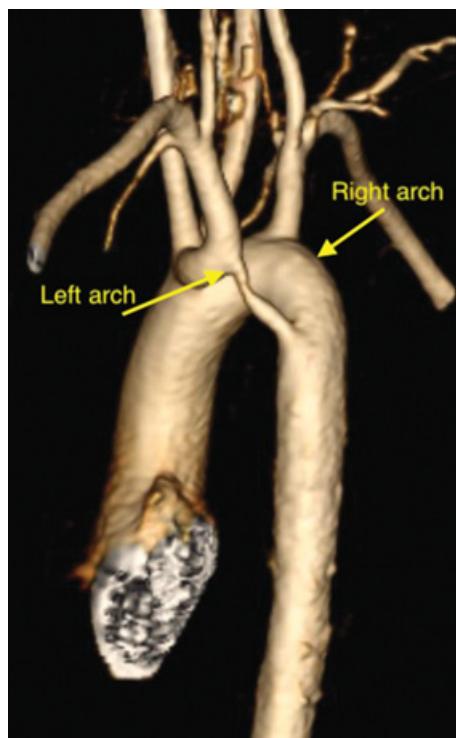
Double aortic arch. 3D magnetic resonance imaging of double aortic arch viewed from the left side. There is a dominant right arch and smaller left arch forming a vascular ring. The trachea and esophagus are contained within the ring. Courtesy of Michael Taylor, MD.
